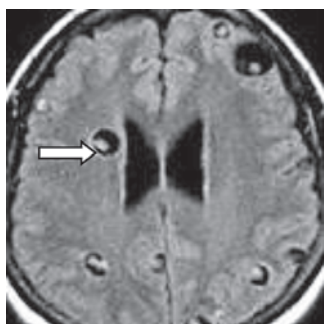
Axial MR FLAIR image shows multiple cysticerci in vesicular stage
